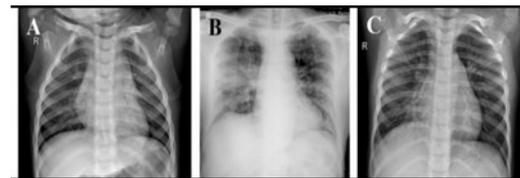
Sample X-ray image from the dataset⁵
